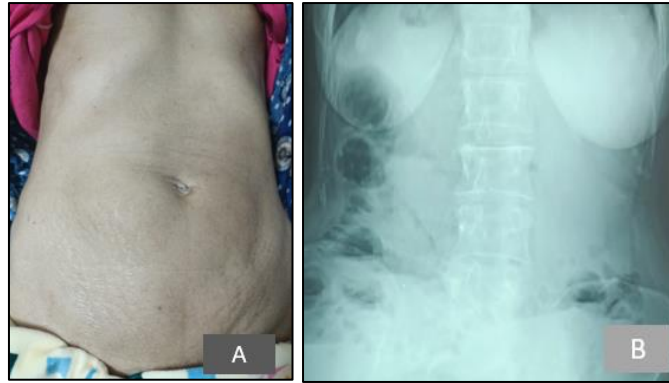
A: lean woman with a distended abdomen. B: Unprepared abdomen X-ray shows hydroaeric levels which are wider than high
